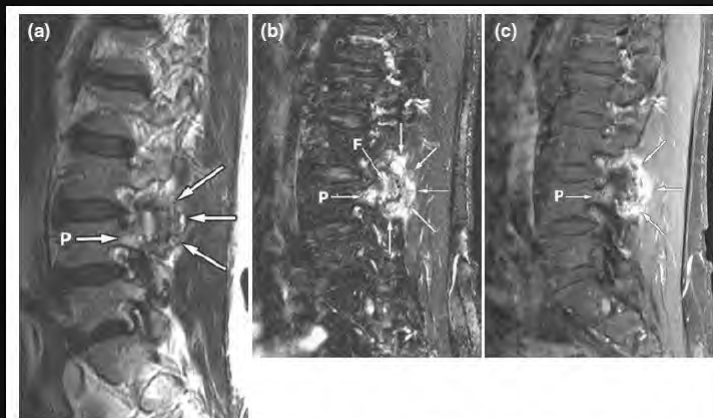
Facet synovitis: the value of sagittal fat-saturated imaging. (a) Right parasagittal T2-weighted spin echo image, obtained without fat saturation, shows enlargement (hypertrophy) of the right L3-4 articular processes and facets (arrows), secondary to osteoarthritis, with thickening of the capsule of the facet joint. Subtle T2 signal hyperintensity is seen in the affected facets as well as in the right L4 pedicle. (b) Right parasagittal T2-weighted fast spin echo image with fat saturation, corresponding to (a). "Hot facet" appearance: intense enhancement in the perifacetal soft tissues (arrows), L3-4 facets (F), and L4 pedicle (P) indicating grade 4 facet synovitis. (c) Right parasagittal contrast-enhanced T1-weighted spin echo image, corresponding to image (a), obtained with fat suppression shows intense enhancement of the right L3-4 perifacetal soft tissues (arrows) adjacent to the enlarged facets and enhancement of the right L4 pedicle (P).
